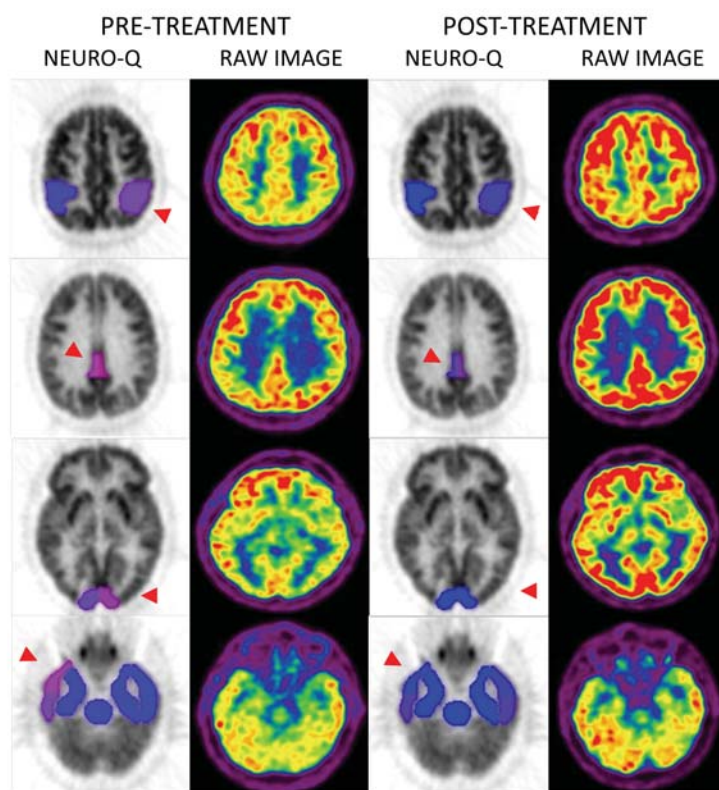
The raw FDG-PET data was processed using NeuroQ software (Version 3.5, Syntermed, Inc Atlanta, USA) and the average pixel values in standardized regions of interest (ROI) were automatically calculated. Area/whole brain ratios were compared to the normal values in the database. Please see that topiramate improved reduced glucose uptake (>2 standard deviations (2 SD's) below normal mean) on the left temporoparietal, right posterior cingulate, right anterior temporal and left posterior visual cortical region.
